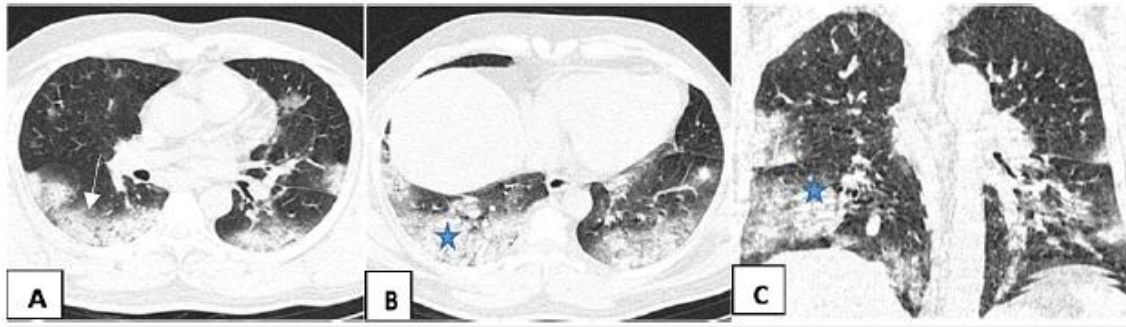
HRCT Thorax of COVID -19 patients.
